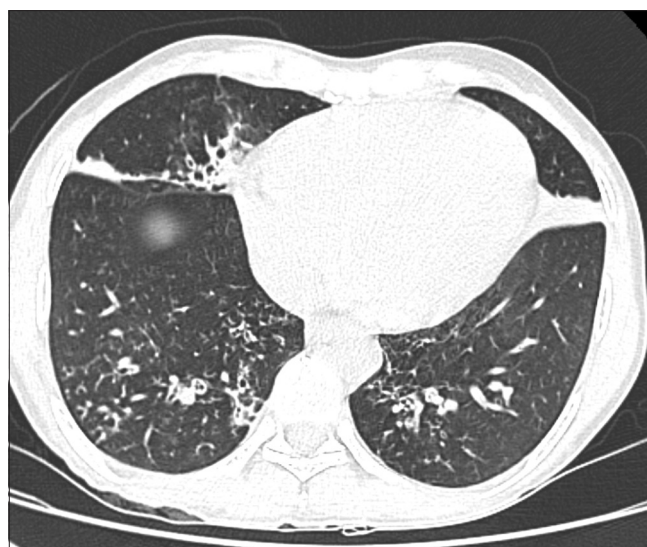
HRCT chest showing centrilobular nodules with tree in bud appearance as well as cylindrical bronchiectatic changes with subsegmental consolidation involving middle lobe and bilateral lower lobes
